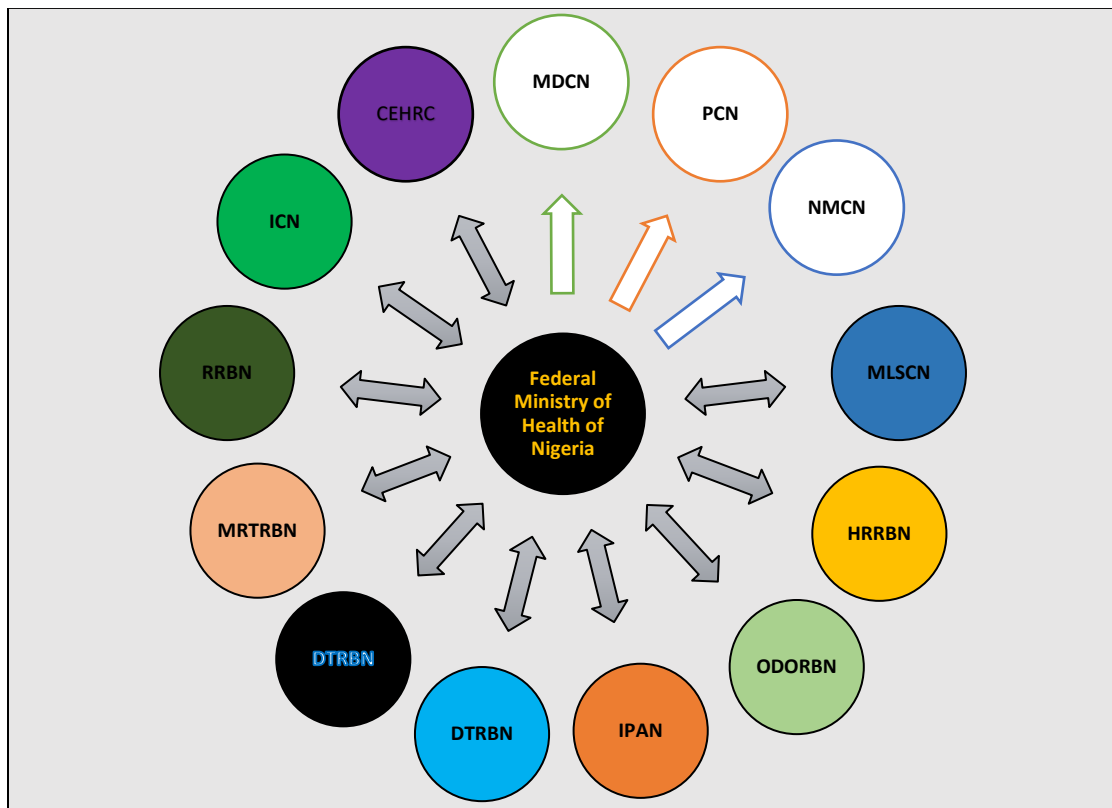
Relationship between the FMOH and its 13 professional health regulatory agencies (PHRA). Medical and Dental Council of Nigeria (MDCN), Pharmacy Council of Nigeria (PCN), Medical Laboratory Science Council of Nigeria (MLSCN), Nursing and Midwifery Council of Nigeria (NMCN), Health Record Officers Registration Board of Nigeria (HRRBN), Optometrist and Dispensing Optician Registration Board of Nigeria (ODORBN), Institute of Public Analyst of Nigeria (IPAN), Dental Technology Registration Board of Nigeria (DTRBN), Dental Therapist Registration Board of Nigeria (DTBN) Medical Rehabilitation, Medical rehabilitation therapist Board of Nigeria (MRTBN), Radiographer Registration Board of Nigeria (RRBN), Institute of Chemist of Nigeria (ICN), Community and Environmental Health Registration Board of Nigeria (CEHRB)
